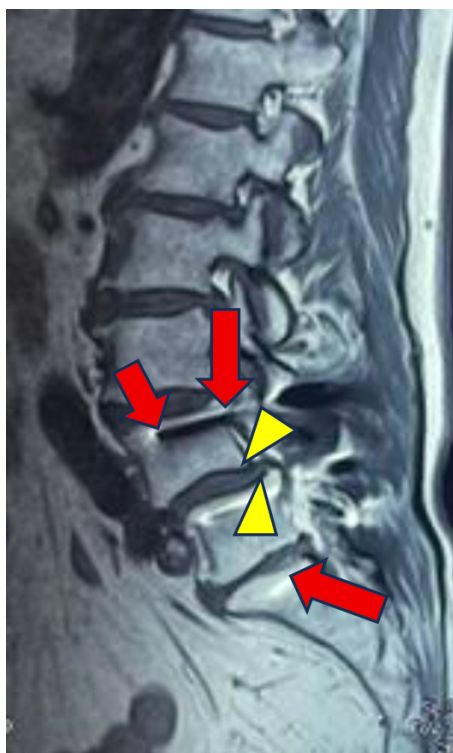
Sagittal magnetic resonance imaging: vertebral stabilization from L4 to S1 with metal screw-plate system (red arrows) in Grade I Meyerding spondylolisthesis of L4 over L5 (yellow arrowheads)
